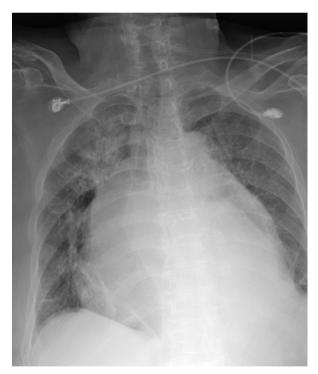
Chest radiograph revealed an opaque lesion occupying 2/3 of the right hemithorax with positive silhouette signs against bilateral cardiac borders and hila, resulting in a water-bottle-like silhouette with a widened mediastinal shadow. Passive atelectasis in adjacent portions of bilateral lungs was also seen. There was no mediastinal shift or tracheal deviation; the right costophrenic angle was spared and the right hemi-diaphragm was normal. These findings indicated a huge, homogenous mass in the mediastinum.
